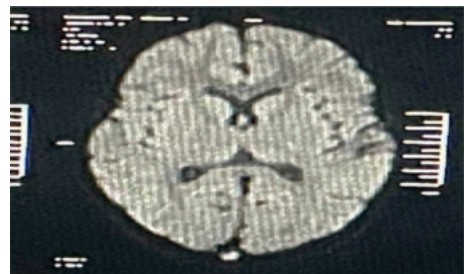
MRI Brain Showing High Signal Intensity In The Posterior Part Of The Sagittal Sinus.
